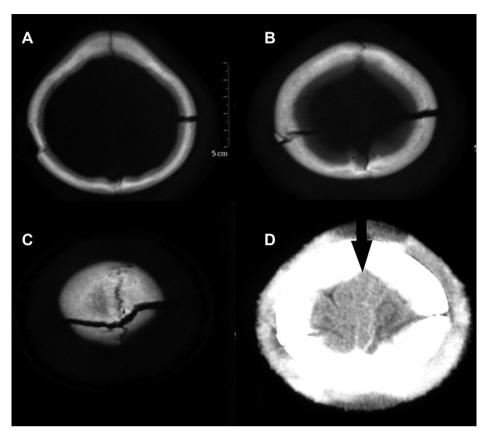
CT scan brain with bone window showing non-displaced, linear, biparietal skull fracture (A–C) with thin acute interhemispheric subdural hematoma (arrow in D).
